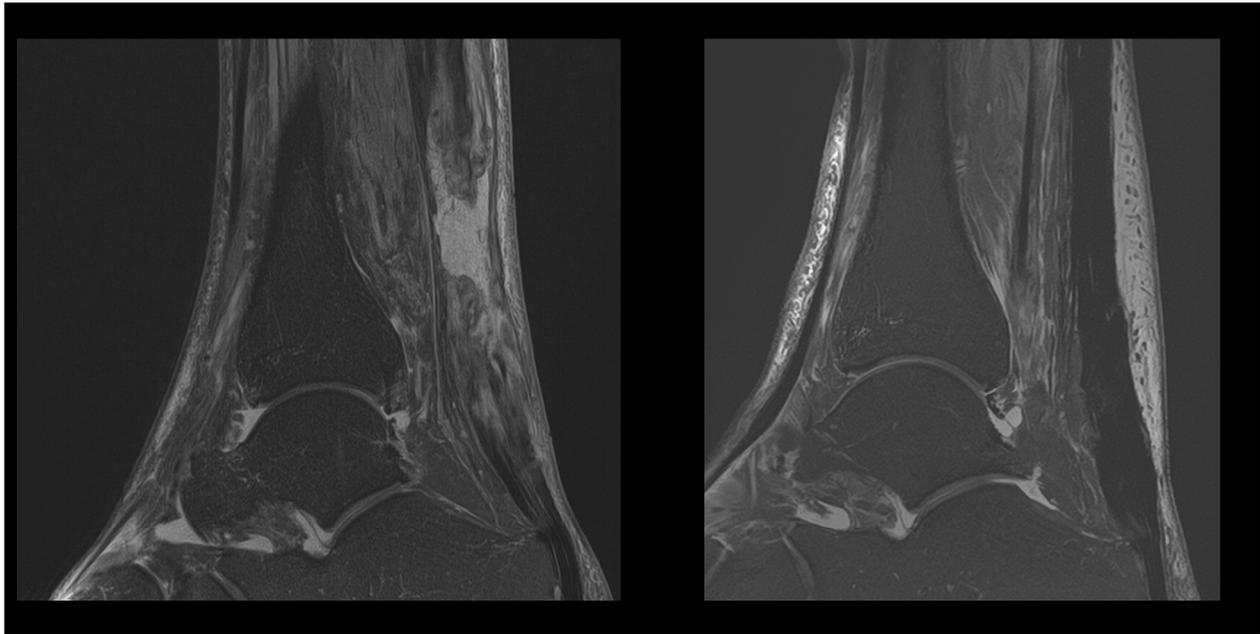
(Case 6): An 85-year-old patient with one year of complete chronic Achilles tendon rupture in the left ankle and failed conservative treatment. A) T2-weighted magnetic resonance imaging (MRI) before local autologous bone marrow mesenchymal stem cell (aBM-MSC; 20×10^6 cells) injection. Lesion gap (20 mm). Absence of tissue. B) T2-weighted MRI at twelve months post-aBM-MSC injection. Post-rupture changes in the middle third with regenerative hypertrophy of the entire tendon and presence of extensive areas of remarkably active granulation tissue of longitudinal disposition without retraction of ends were observed. Almost complete tissue regeneration of chronic Achilles tendon rupture (95%) was achieved. No adverse events. The patient resumed playing tennis after four months.
